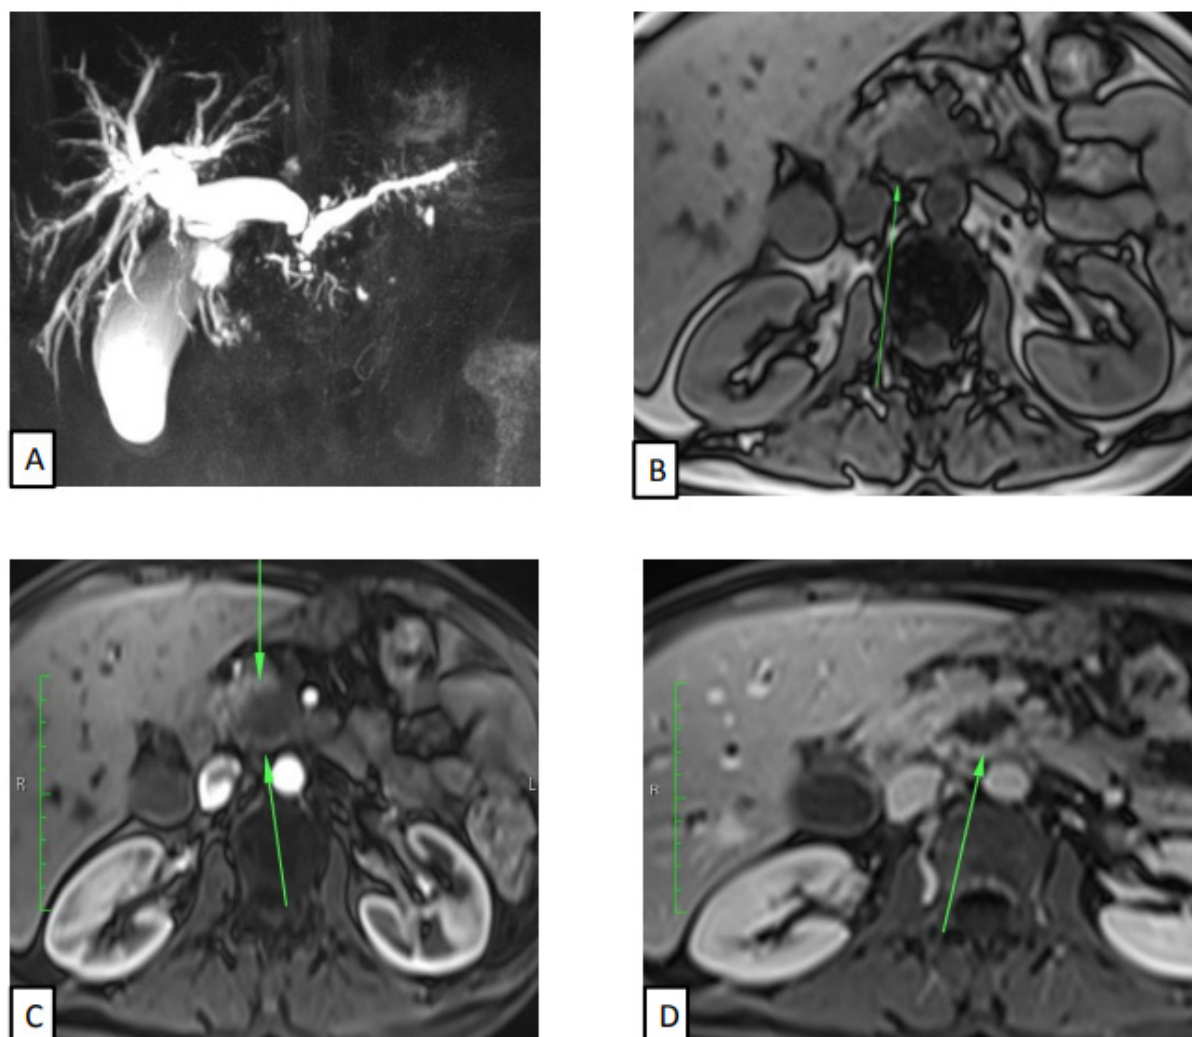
61-year-old male patient. On MRI examination, MRCP series (A) showed dilatation of the biliary tract and pancreatic duct, which terminated abruptly at the level of the pancreatic head, and T1-weighted out-of-phase in the area corresponding to this localisation. There is a mass lesion (arrows) which is hypointense compared to the muscles in the images (B), doesn't show a significant contrast enhancement in the arterial phase images after IVCN (C), but in the late phase images (D), there is a circumferentially contrasted mass lesion (arrows) except for the central non-contrasting necrotic area. Intraoperative biopsy was performed and the result was evaluated as chronic pancreatitis. Afterwards, USG-guided core needle biopsy was performed and resulted as adenocarcinoma. As a result of the follow-up clinical findings and imaging examinations, progression was detected in the findings accompanied by liver metastasis. The clinical diagnosis of the patient is pancreatic adenocarcinoma.
